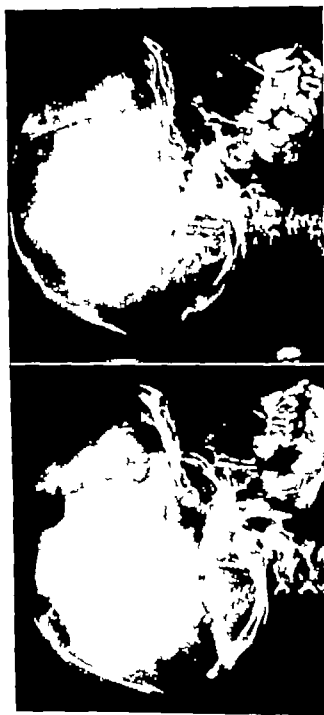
Skull changes in Hand-Schüller-Christian syndrome. A Appearance before treatment. B Appearance after mild doses of roentgen therapy
